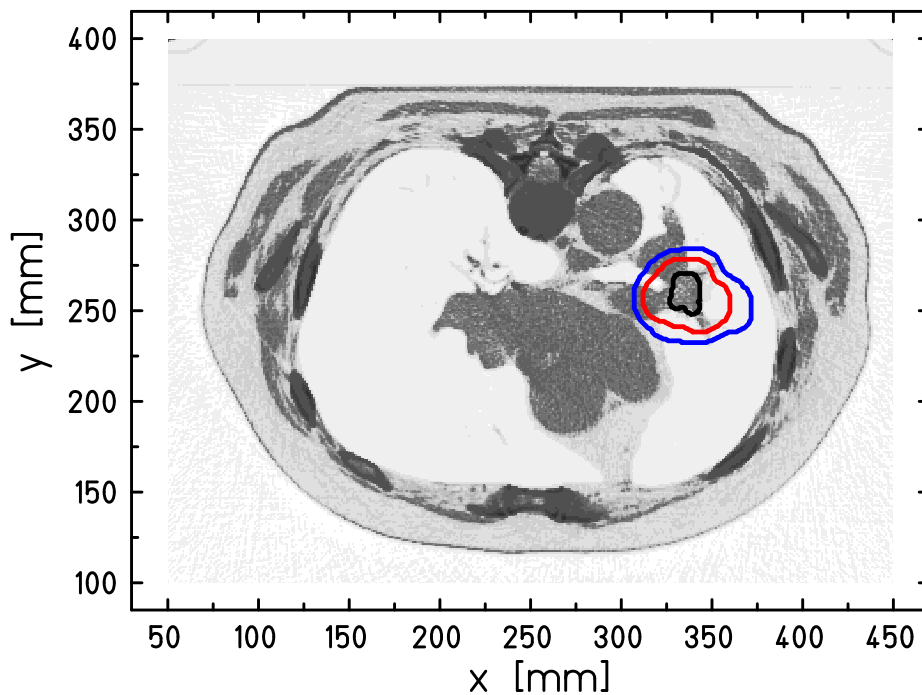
CT slice of a lung tumor patient. GTV (black), CTV (red), and PTV (blue) contours delineated. Definitions of GTV, CTV, and PTV are given in the Section 1.4.3.
